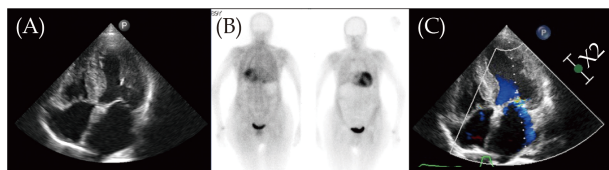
Early diagnosis of cardiac amyloidosis. (A): Point-of-care ultrasound; (B): cardiac gammaigraphy; and (C): transthoracic echocardiogram.
